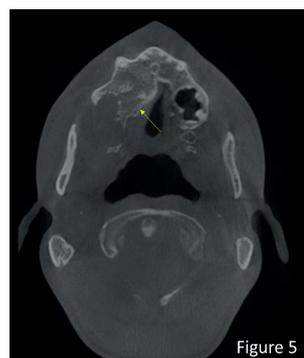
CBCT in 2023 showing the bony changes in the right maxilla (yellow arrow).
